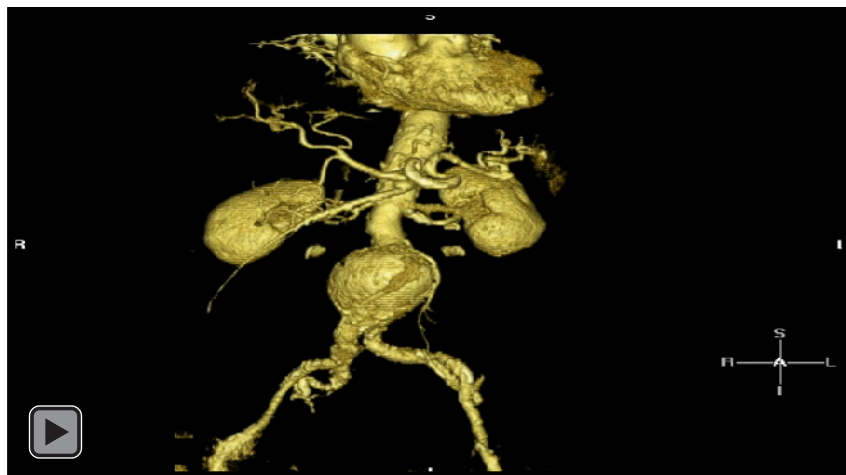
(movie). CT angiography of a ruptured AAA. 3D MIP (maximum intensity projection) images demonstrating only selected structures. University of Massachusetts Medical School, Department of Radiology.
